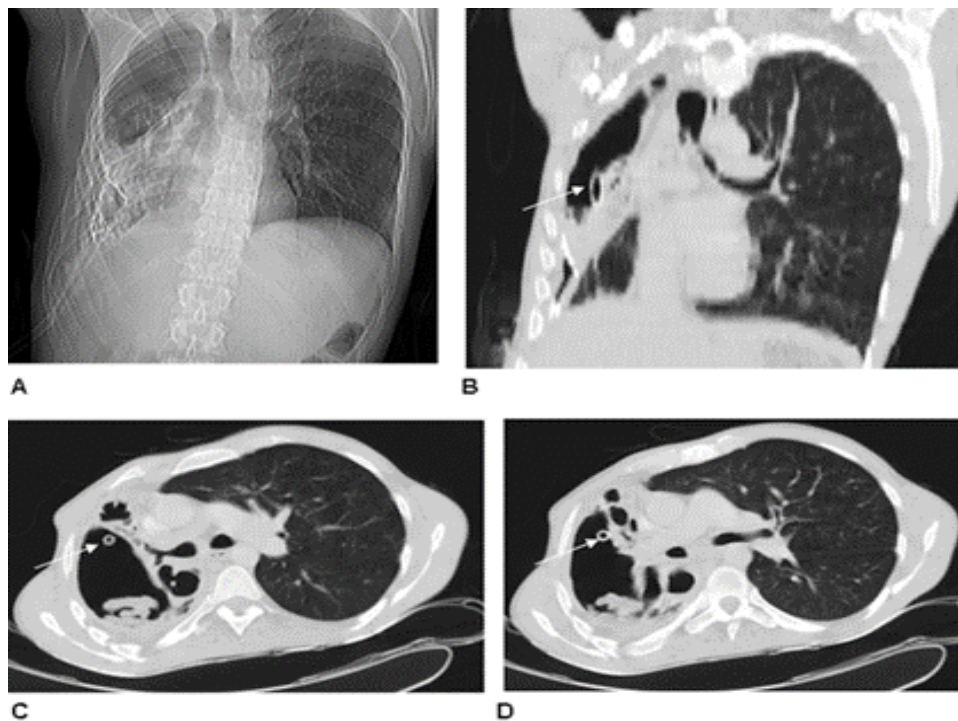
(Case 14): 43 yrs old male presented with chest pain and dyspnea with the CXR and CT scans showing a destroyed right lung with thickened and calcified pleura with a chest tube (arrows) in the destroyed
